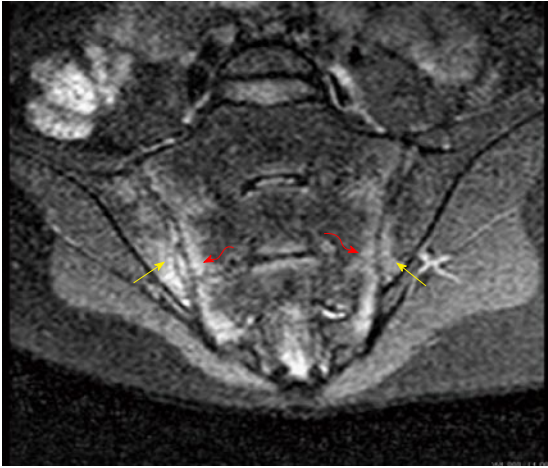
Oblique coronal magnetic resonance imaging (short tau inversion recovery sequence) of a patient with active ankylosing spondylitis revealed bilateral high signal intensity in both the sacral and iliac components of the sacroiliac joint.
